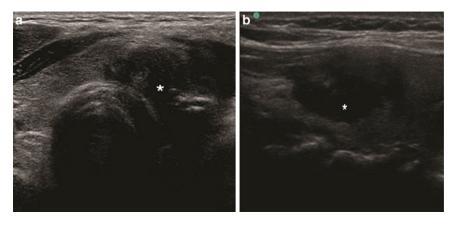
Ultrasound features of locally invasive papillary thyroid cancer. (a) Primary papillary thyroid cancer (*)
